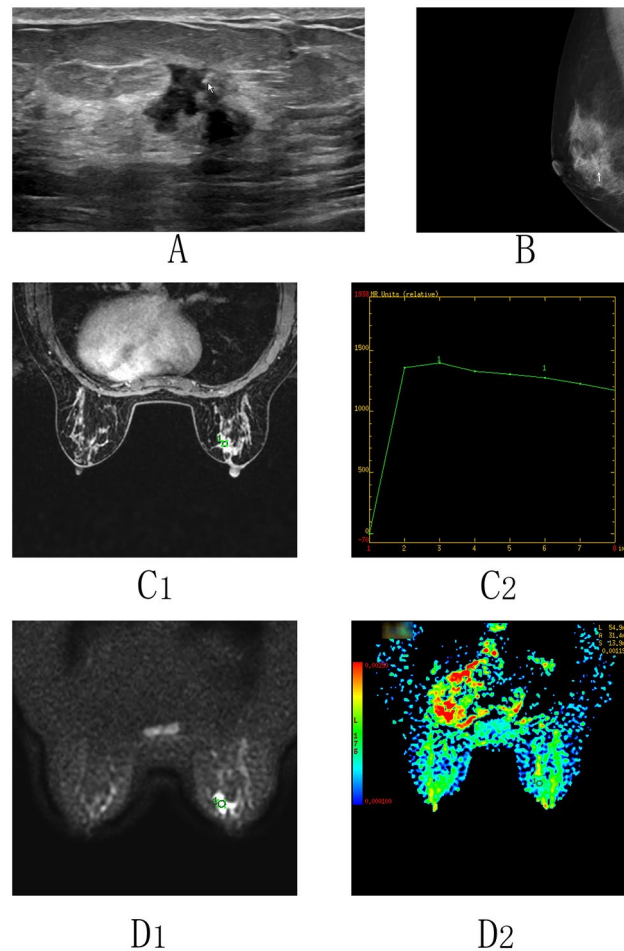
Ultrasound, mammography, and MRI images of breast cancer patients with HER-2 expression (1+). Female, 51 years old, infiltrating ductal carcinoma in the right breast, HER-2 (1+). A: Ultrasound shows the hypoechoic mass surrounded by hyperechoic halo (white arrow). B: Mammography shows local glandular aggregation with sandy-like calcification (white arrow). C1: Enhanced MRI image shows the mass is clearly enhanced with high signal. C2: The TIC (time-intensity curve) shows a slow outflow type. D1: Significantly high signal of the mass seen in DWI imaging. D2: Mean ADC value in the corresponding region of interest is 0.000818.
